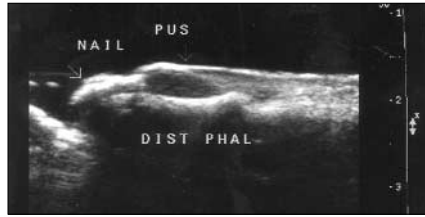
Ultrasound scan showing pus below the epidermis.
